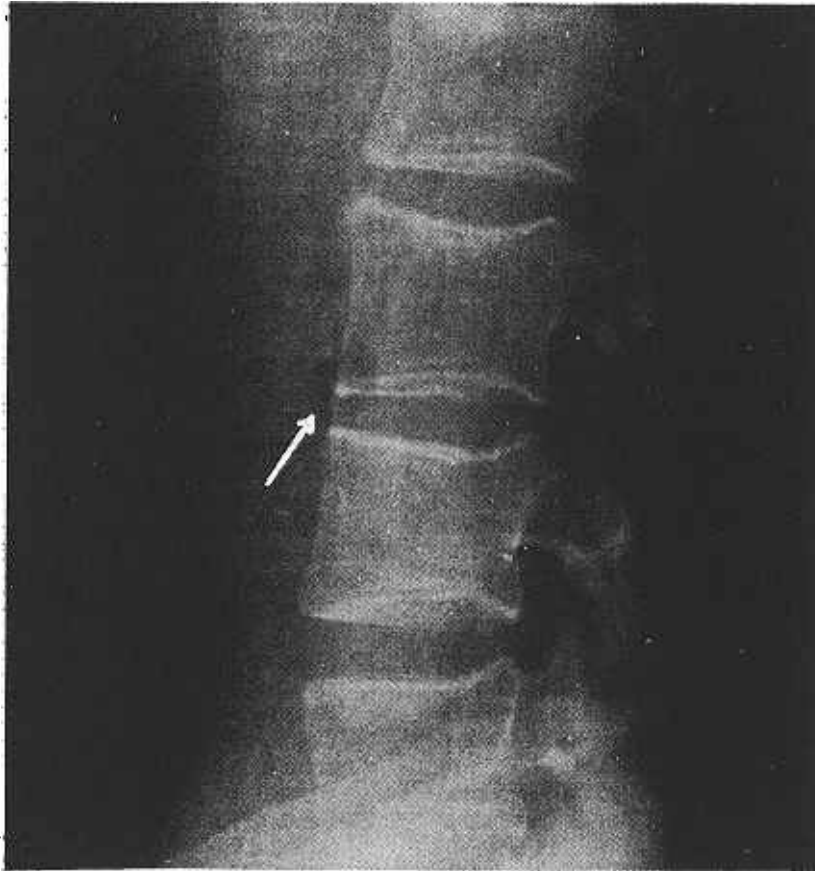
Lateral x-ray of the lumbar spine reveals typical early changes including demineralization and squaring of vertebral bodies as well as ligamentous calcification from L₃ to L₄ (arrow).
